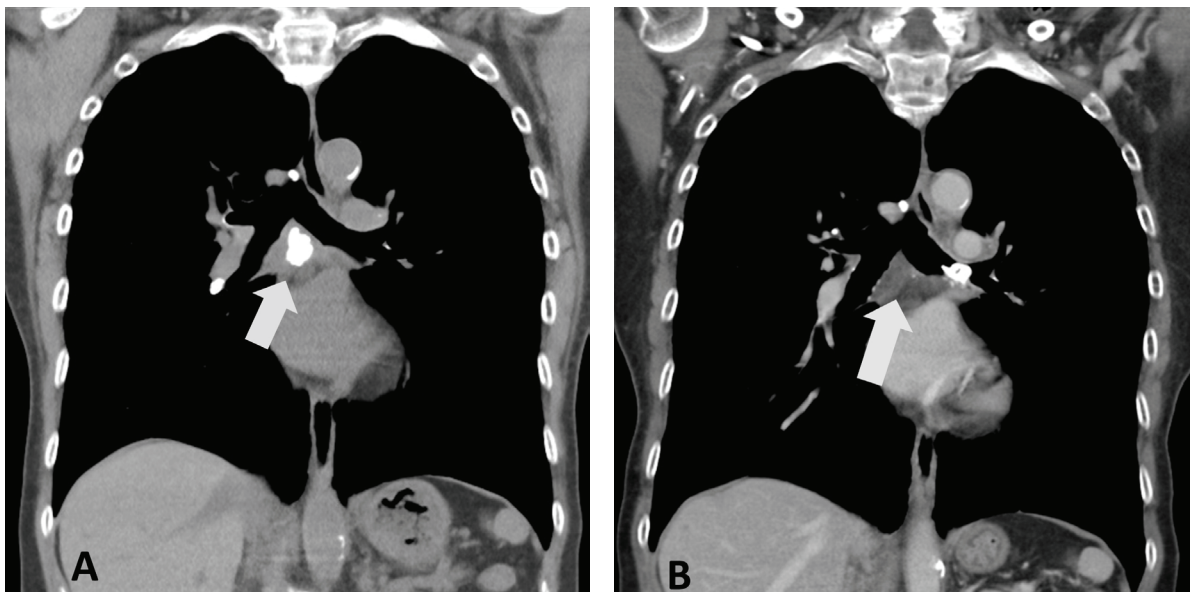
A. Presence of subcarinal lymph node calcification on chest CT 3 years prior to this hospitalization; B. Disappearance of the subcarinal calcification during this hospitalization.
